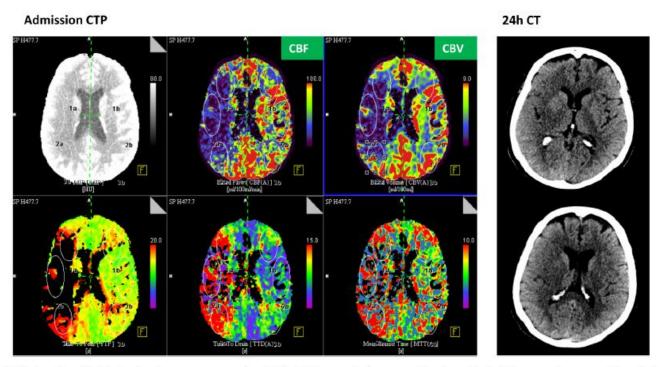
Patient with a final infarct volume on non-contrast CT at 24 hours that was smaller than the initial core volume on CT perfusion (CTP) at admission. In this patient the onset to CTP time was 51 min and the time from symptom to recanalization was 110 min. National Institutes of Health Stroke Scale at 24 hours was 2. CBF, cerebral blood flow; CBV, cerebral blood volume.
